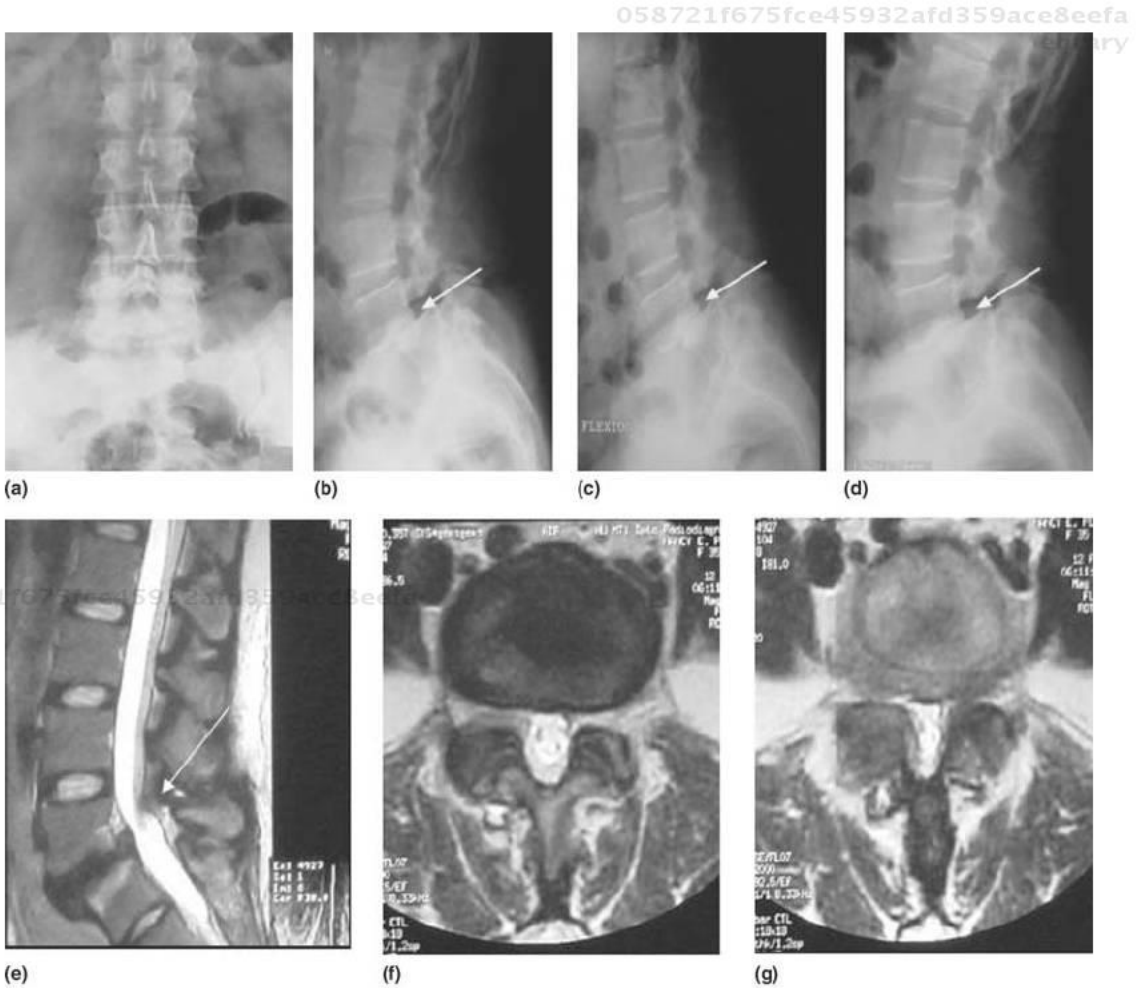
Diagnosis and treatment of isthmic lytic spondylolisthesis. (a) through (d) Presurgical x-rays. Dynamic x-rays in flexion (a) and (c) and extension (b) and (d) show signs of instability with translation of L5 over S1. (e) Sagittal T1-weighted magnetic resonance image that shows a narrow lumbar canal at the levels of L5–S1. (f) T1-weighted magnetic resonance image that shows a narrow lumbar canal. (g) T2-weighted magnetic resonance image that shows a narrow lumbar canal. (h) and (i) Postoperative x-rays. (j) and (k) Postsurgical x-rays at 2 months. Courtesy of Pedro Martín Reyes-Fernández, M.D.
